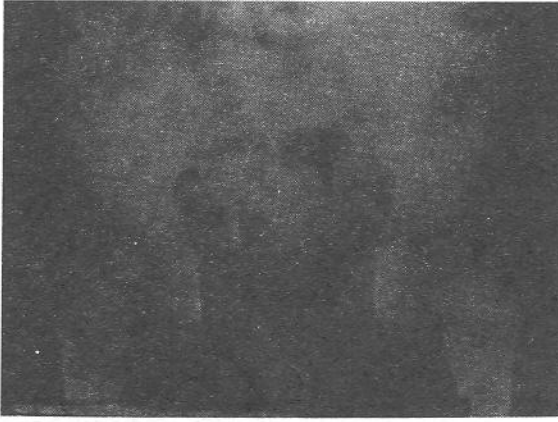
Plain X-ray film of a bladder stone.
